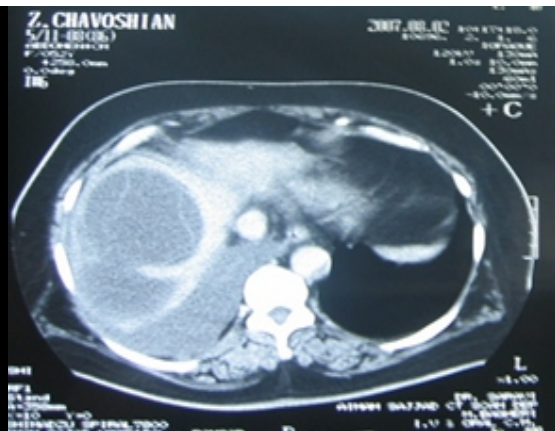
CT-scan of the chest show intrapleural ruptured of liver hydatid cyst
